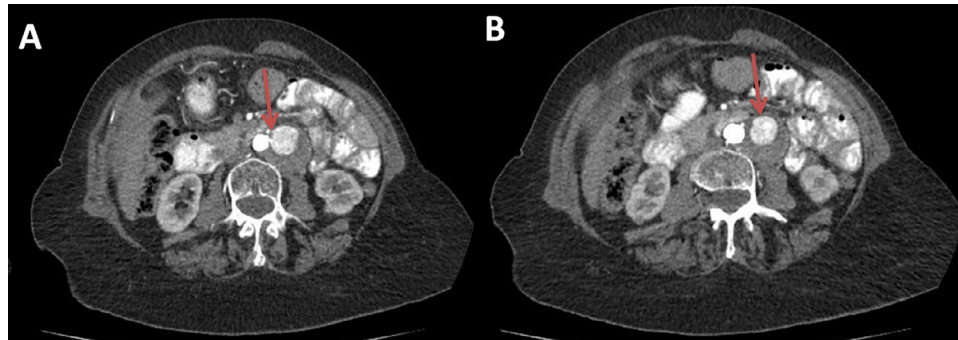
CTA revealed a focal tear on the calcified arterial wall (1 - A, arrow) that caused the eccentric saccular aneurysm (1 - B, arrow).
